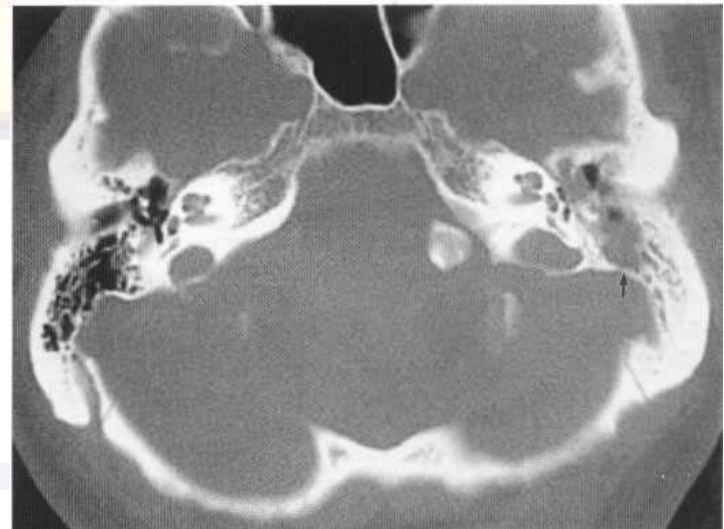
Axial CT scan showing fluid in the mastoid cell system on the left (arrow), with cell wall breakdown.
